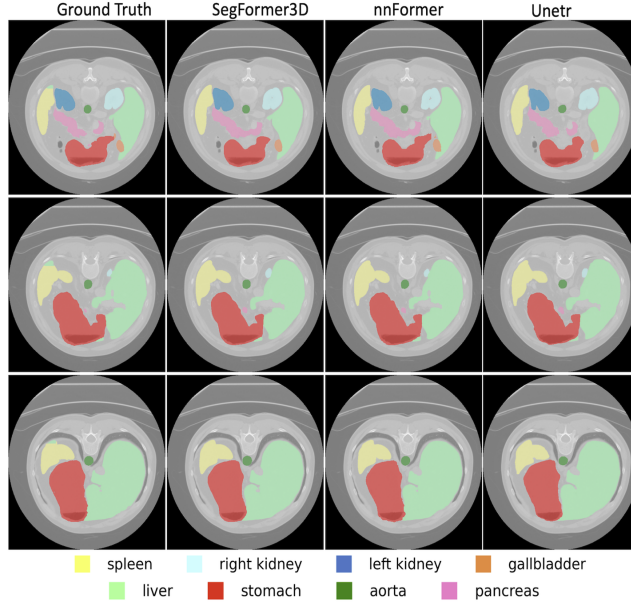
Qualitative results on Synapse. Each row is a separate frame in the CT sequence while each column is different 3D volumetric image segmentation solution. Each organ mask is highlighted with a unique color code. We qualitatively demonstrate highly accurate segmentation performance compared to well established SOTA methods while maintaining a lightweight design.
